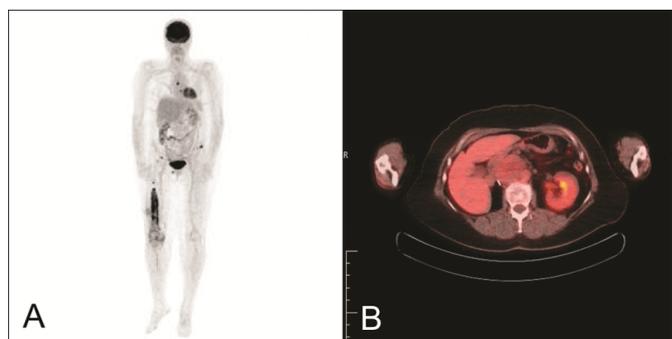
(A–B): FDG PET images. (A) PET-CT image showing increased uptake at right femur. (B) PET-CT image showing low glucose avidity in enlarged retroperitoneal nodes.
